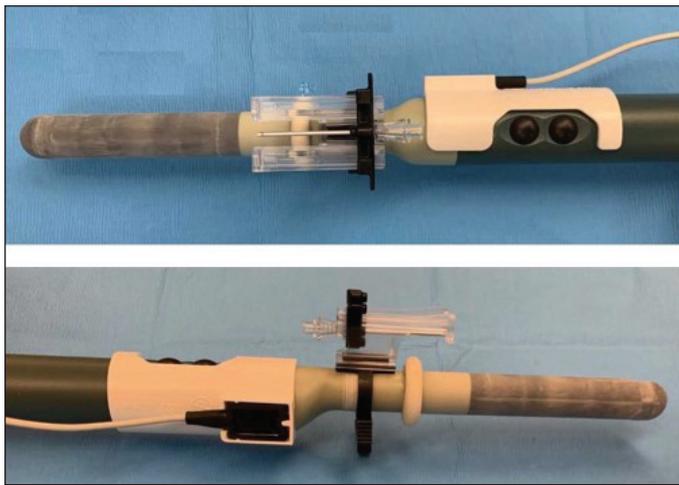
Biopsy probe setup. BK 8848 Biplanar Ultrasound Probe with PrecisionPoint Transperineal Access System and tracker for field generator attached.
